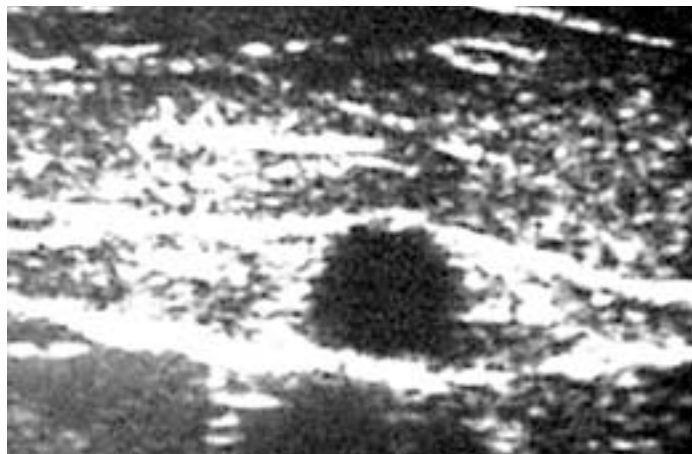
Shown is an ultrasonographic image of the so-called saphenous eye. Correct identification of this marker is crucial to correct performance of the preoperative ultrasonographic reflux examination.
